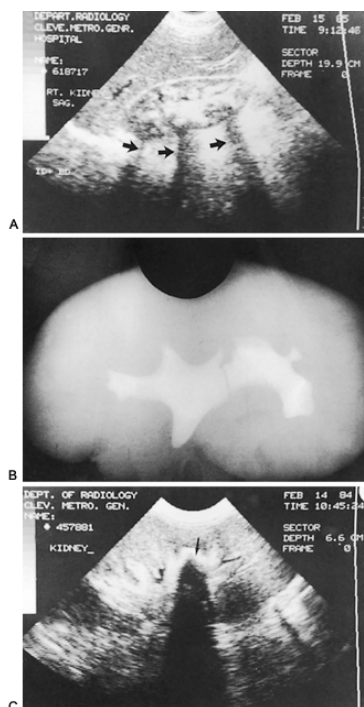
52. A: Preoperative renal scan of large staghorn calculus. Note multiple areas of acoustic shadowing (*arrows*). B: Intraoperative radiograph before nephrotomy. C: Intraoperative ultrasound localizing small retained stone fragment (*arrow*).
